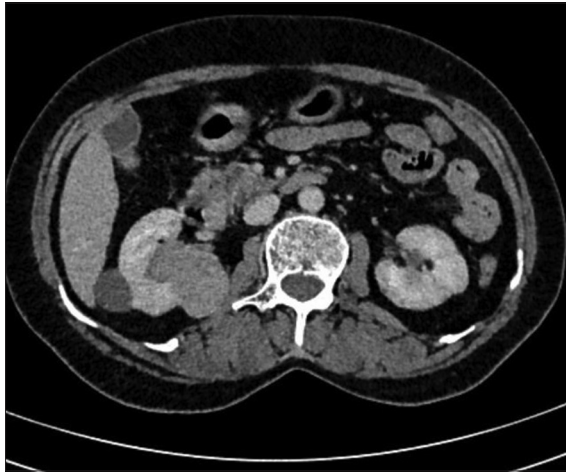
Contrast-enhanced computed tomography scan showing right renal metastasis
